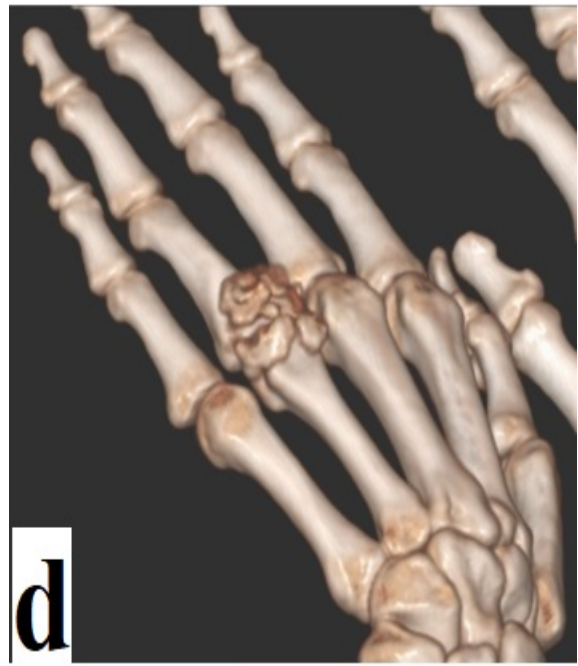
3D CT scan, a general view*
